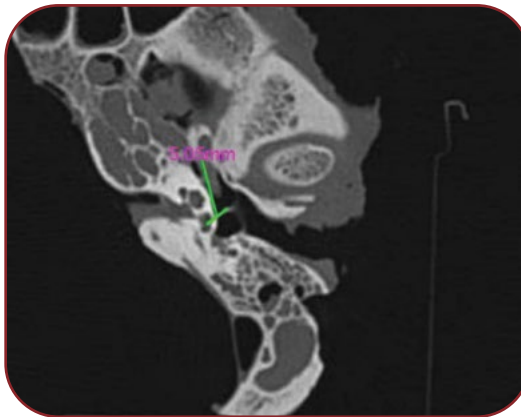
Distance between the stapes and round window on a multi-detector computed tomography (MDCT) image
